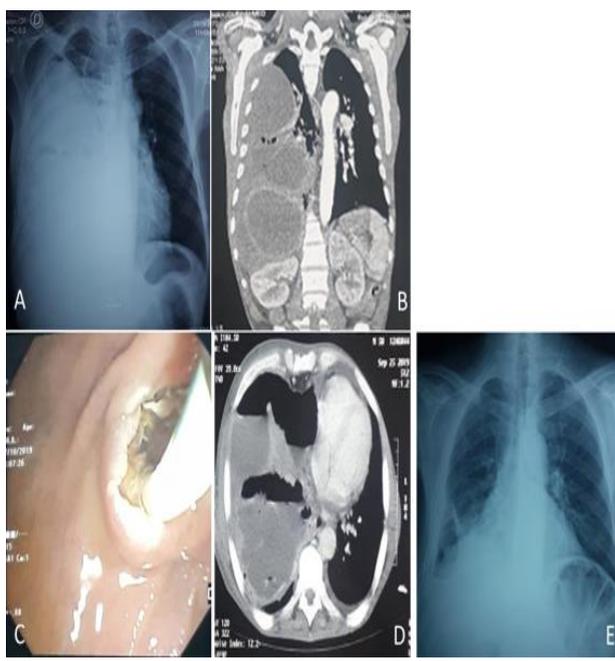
Patient#2 imaging and endoscopic Iconography: A. Chest x-ray showing profuse pleural fluid effusion B. Abdominal chest CT scan showing hepatic dome hydatid cyst communicating with lung abscess and a pleural collection. C. Post endoscopic sphincterotomy image with bile and removed material. D. Post sphincterotomy and post-pleural drainage chest CT showing a regression of pleuro pulmonary lesions but persistence of a basal pleural collection. E. Post-operative chest x-ray.
